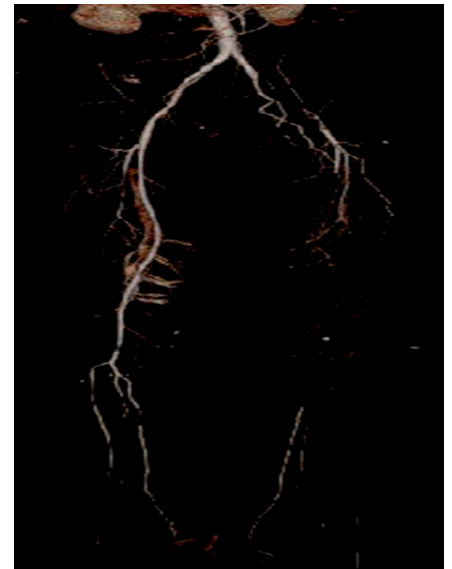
Left external iliac artery occlusion. CTA of a 40-year-old HIV-positive male patient who presented with left lower limb rest pain and gangrene of the foot. He was offered an above-knee amputation.
